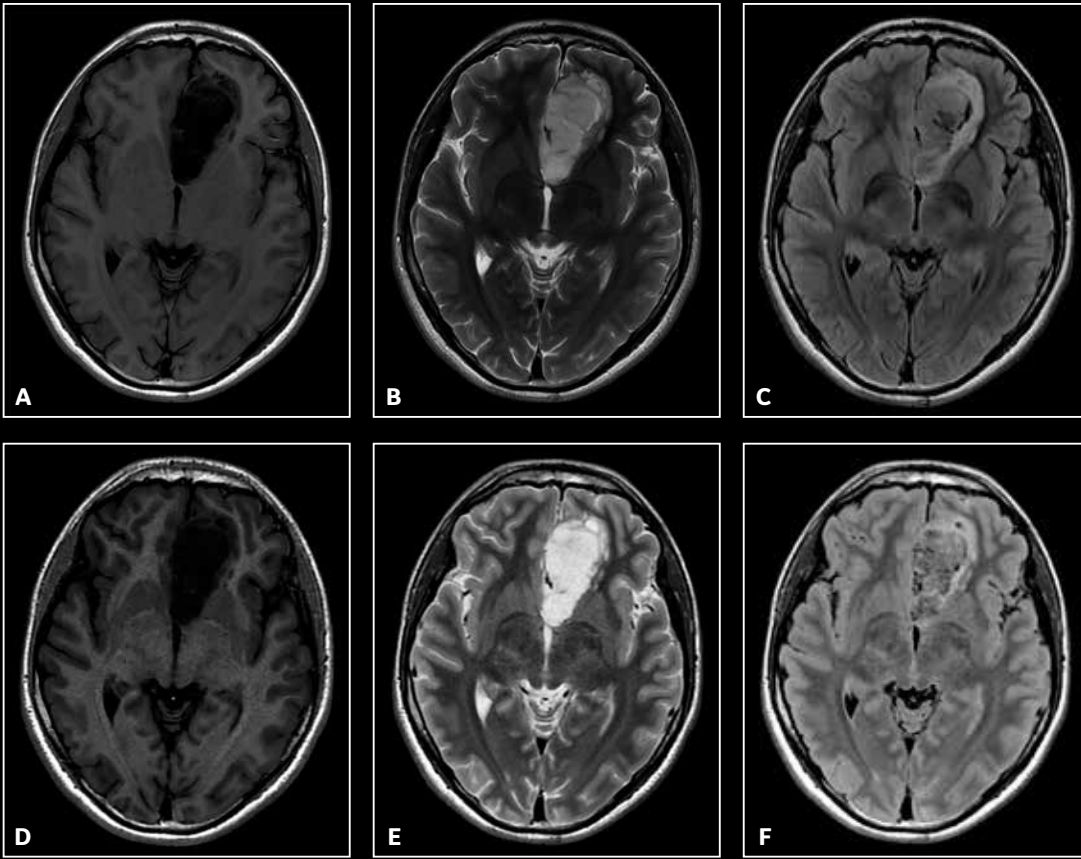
(A) Conventional T1, (B) T2 and (C) FLAIR sequences. (D) MAGiC T1, (E) T2 and (F) FLAIR sequences.
